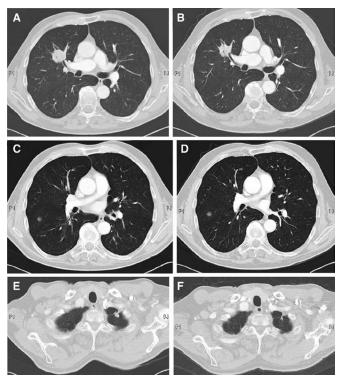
Computed tomography scan at time of first presentation and after six cycles of chemotherapy. *A*, Shows a reduction of the lesion in the right upper lobe. *B*, Shows an unchanged right middle lobe lesion. *C*, Shows a clear reduction of the left upper lobe lesion.
